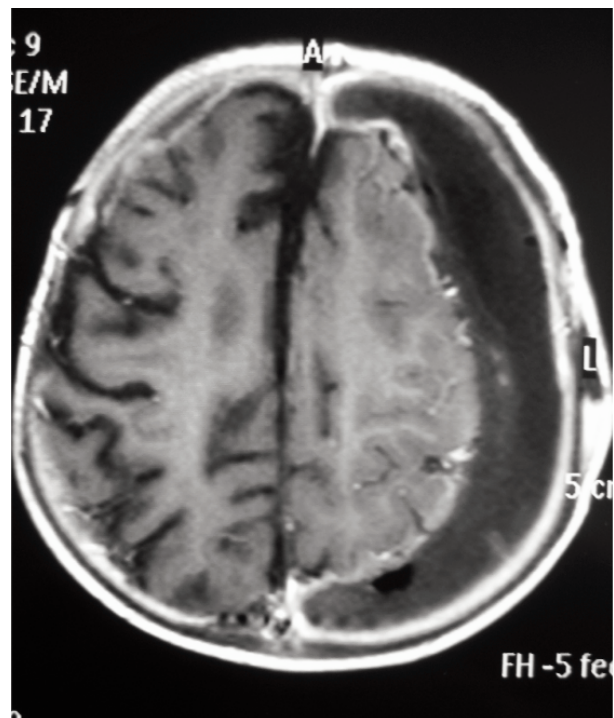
Axial T1W1 contrast-enhanced MRI showing enhanced contrast around the left subdural frontoparietal region.
